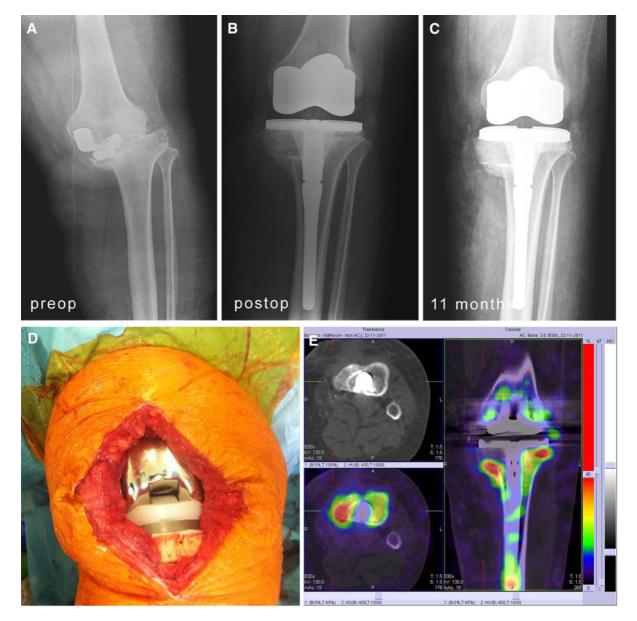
Proximal tibia graft. a A preoperative X-ray of a Engh (AORI)type T2/b tibial component loosening. b, c Postoperative X-rays immediately after surgery or 12 months later. A "Z" form allograft was applied according to the extent of the bone loss and shaped to the contour of the revised tibial component. At 12 months the gap had become filled and although it is still visible, there are signs of calcified tissues filling the gap. d An
